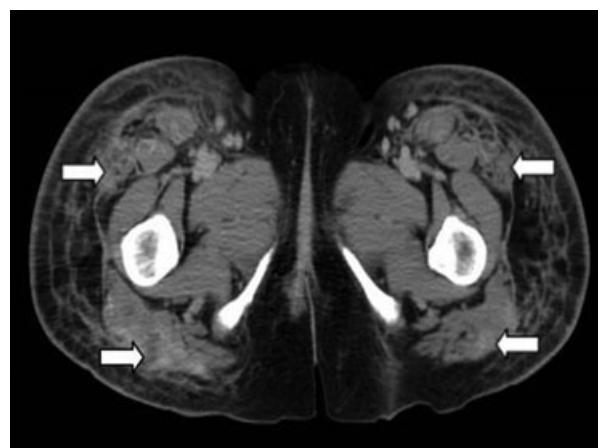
The computed tomography of the lower extremities showed multiple intramuscular low-attenuated lesions with peripheral enhancing rims in the bilateral gluteus, adductor, and quadriceps muscles (arrows).
